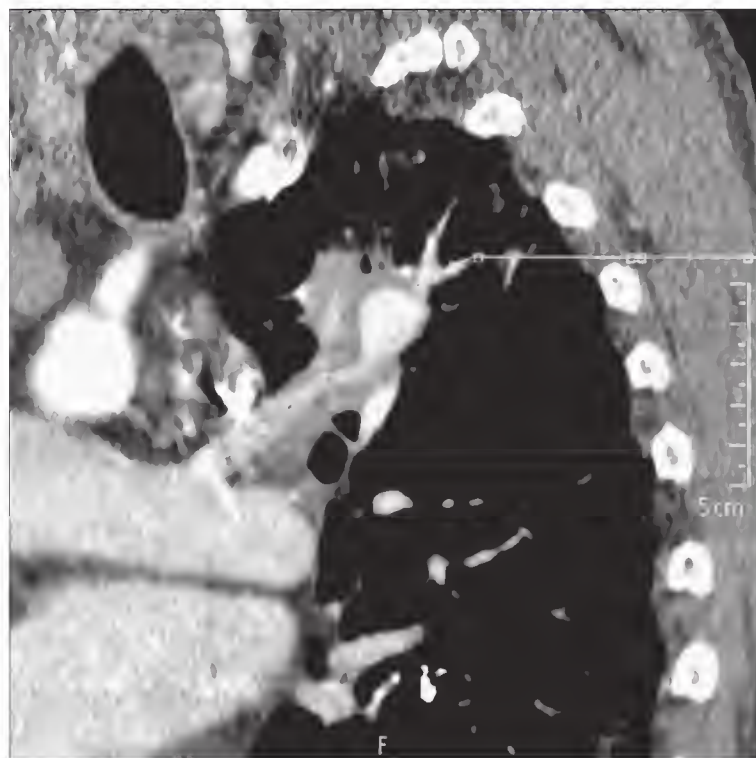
Pulmonary artery aneurysm shown on computed tomographic pulmonary angiogram in a patient with Behçet syndrome and pulmonary hypertension.
